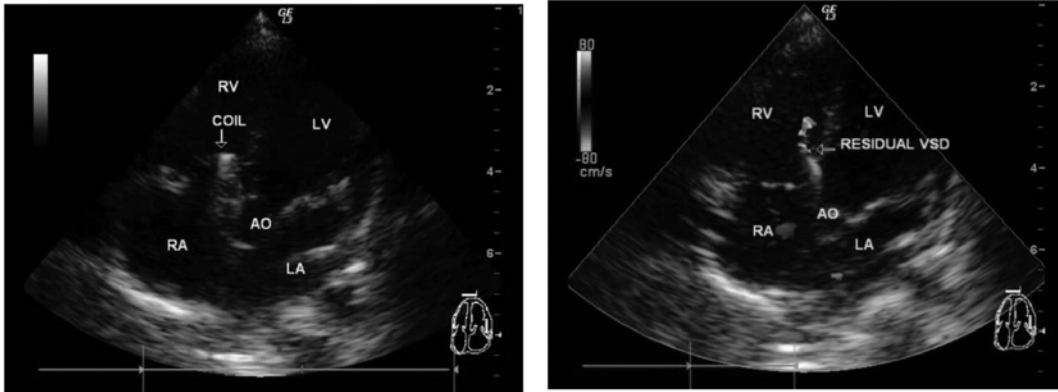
Echocardiography 2 weeks post catheterization showed coil in situ, small residual VSD and trivial AR.
